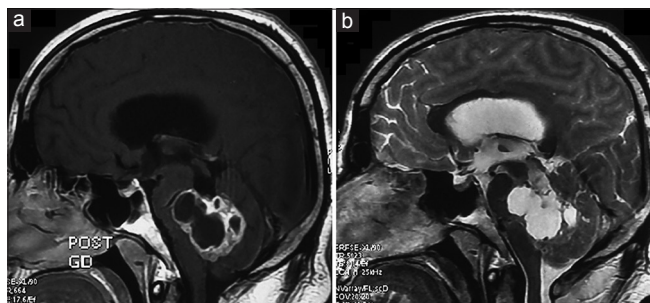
Postcontrast T1-weighted image (a) and T2-weighted image (b) show an irregular complex cystic heterogeneously enhancing mass measuring 42 mm × 39 mm × 35 mm in region of fourth ventricle, abutting brain stem
